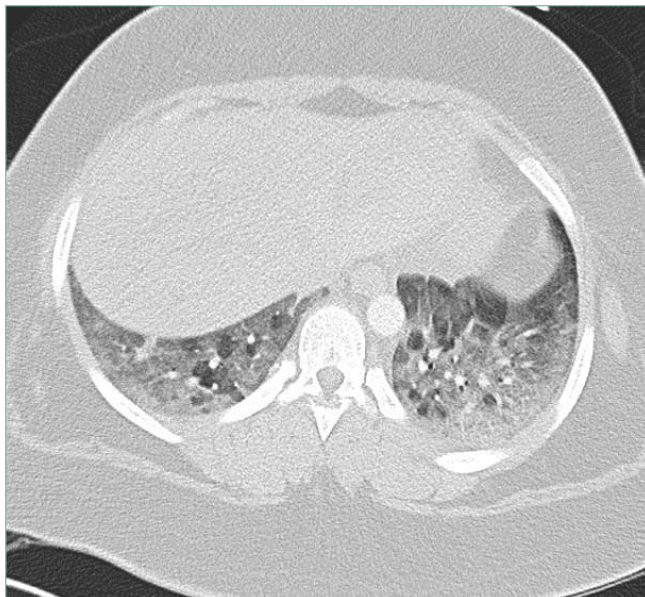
Axial Chest CT demonstrating diffuse centrilobular ground-glass opacities and patchy areas of lobular air-trapping with mosaic attenuation seen most prominently in the bilateral lower lobes.
